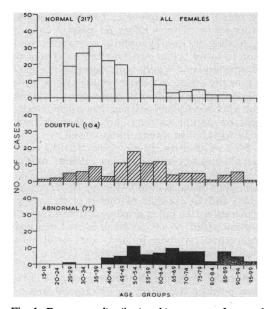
Frequency distribution histograms of normal, doubtful and osteoporotic X-rays among 398 films examined in various countries without prior knowledge of the patient's age or sex. Note the onset of osteoporosis in the fifth decade
